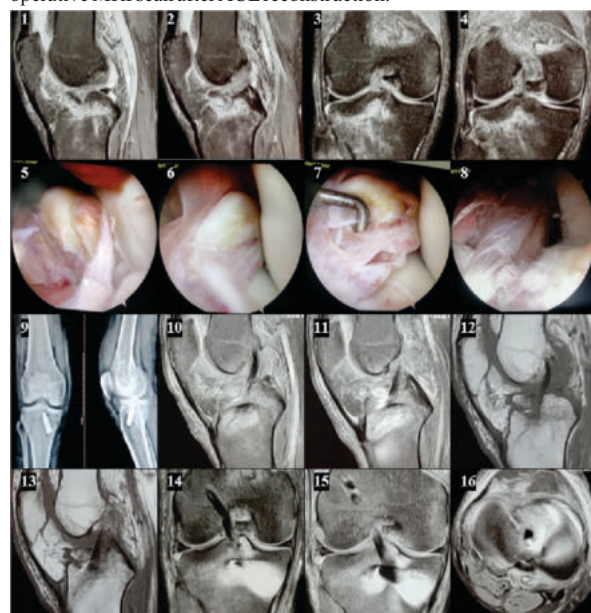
Images 1-4 are of pre-operative MRI scan showing displaced tibial spine avulsion fracture and altered interstitial signal of ACL. Images 5-6 show arthroscopy findings of displaced tibial spine
